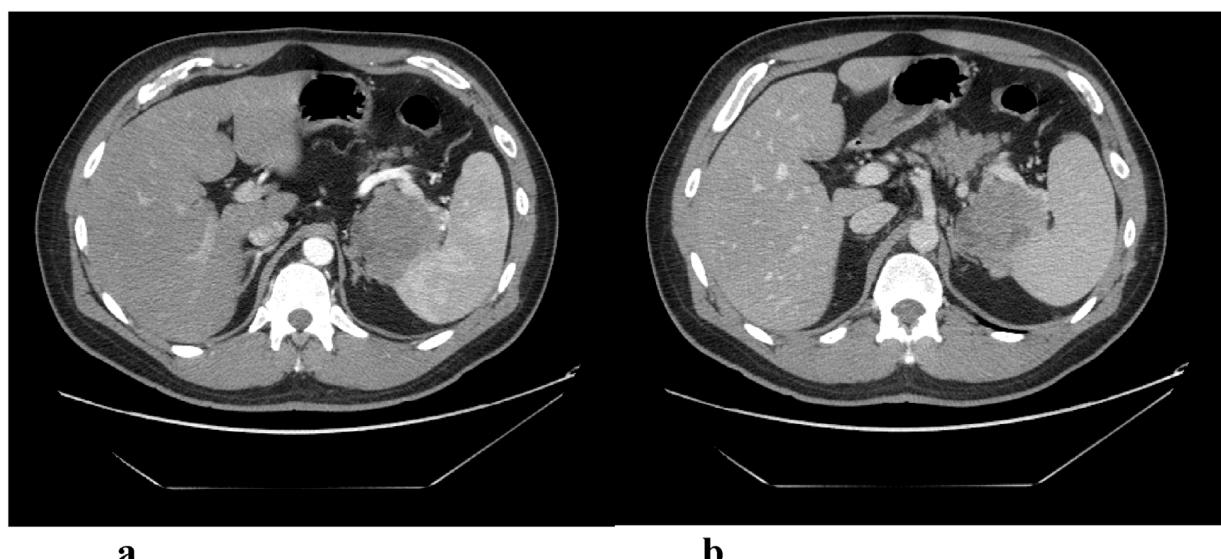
a and b: CT with contrast enhancement during portal phase show a voluminous mass next to splenic hilum with splenic vein infiltration.
